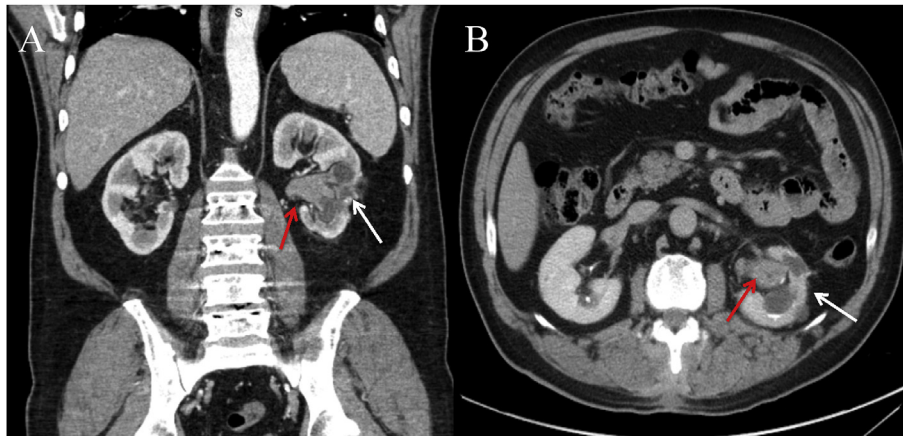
Postoperative computed tomography (A) coronal and (B) axial demonstrating a 2.1×1.7 cm soft tissue mass occupying the left renal collecting system (red arrow) as well as postsurgical changes of the previously visualized left renal mass (white arrow).
